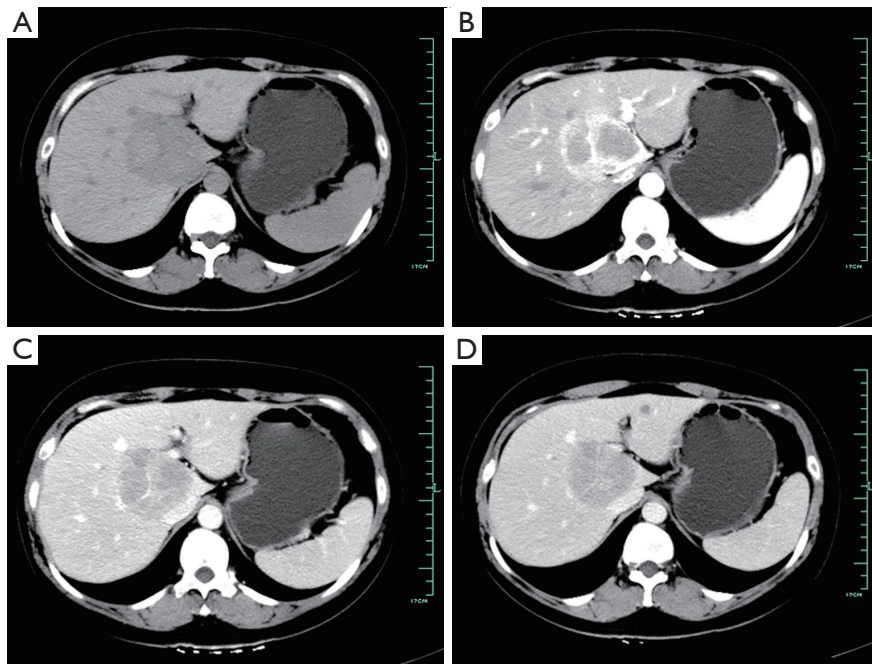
A 34-year-old female with left upper abdominal pain. (A) A plain CT scan shows a heterogeneous hypodense hepatic mass adjacent to the second hepatic hilum. (B) An arterial phase image shows peripheral enhancement and septal enhancement of the mass. (C,D) Portal phase and delayed phase images show an enhancing hypoattenuating mass with septal enhancement.
